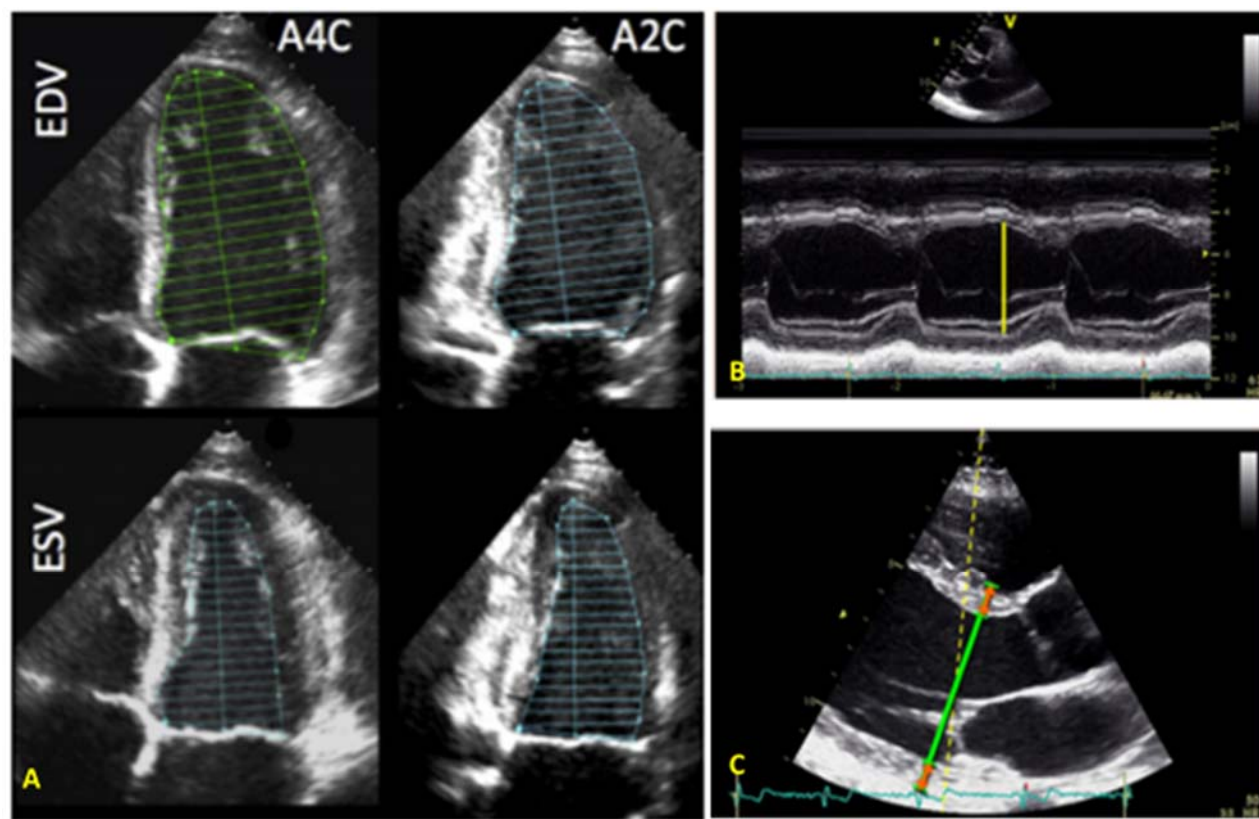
(A) Still frames of two orthogonal planes at end systole and diastole to calculate LV volumes and ejection fraction by modified Simpson; (B) measurement of LV end-diastolic diameter by 2-D guided m-mode; (C) Measurement of LV linear dimensions by 2-D, electronic calipers should be positioned on the interface between myocardial wall and cavity and the interface between wall and pericardium (orange arrow). [Journal of the American Society of Echocardiography 2015 28:1-39.e14DOI: (10.1016/j.echo.2014.10.003) Copyright © 2015 American Society of Echocardiography]
